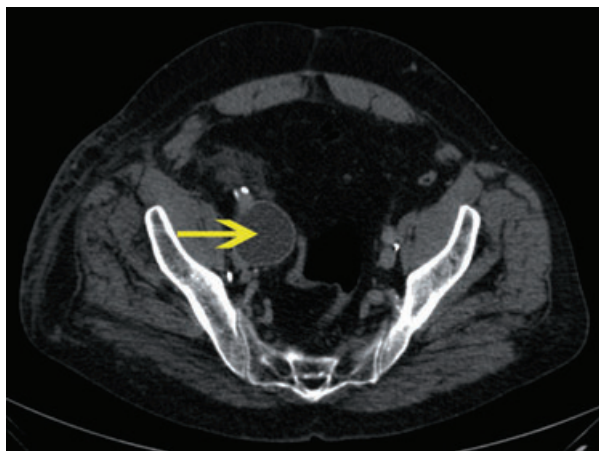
CT scan showed external compression of the right iliac vessels due to reservoir position (yellow arrow).
